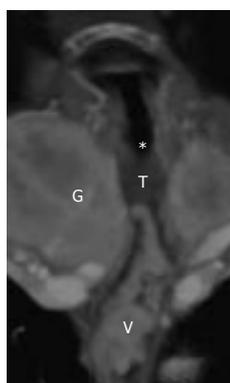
3D reconstruction of CT angiography with view at the dorsal wall of the trachea (T) demonstrating a venous plexus of downhill varices (V) on the wall between the esophagus and trachea connected with a thyroid vein at the goiter (G) of the right thyroid lobe; *, out of plane, cut off level thick slice.
